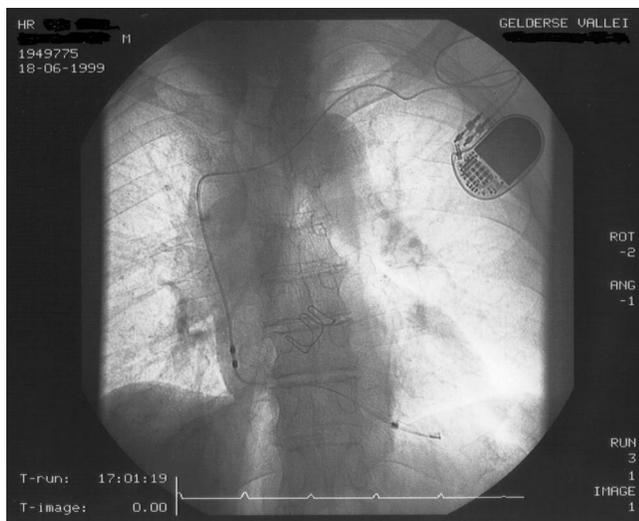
Antero-posterior X-ray of the implantation. Note the slack in the single pass lead and the position of the atrial dipole in high-mid level of the right atrium, and the stent of the valvular aortic prosthesis.
